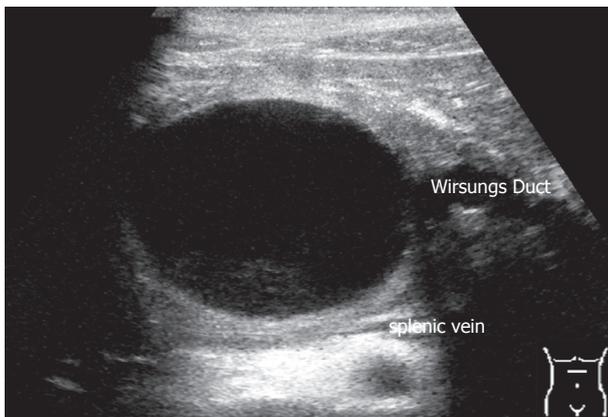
Pseudocyst at conventional and echo-enhanced ultrasound A: A lesion with an echo-free pattern and a sharply delineated wall. The Wirsungs Duct is dilated; B: A highly vascularized wall (maximum of contrastation 20 s after injection of the echo-enhancer).
